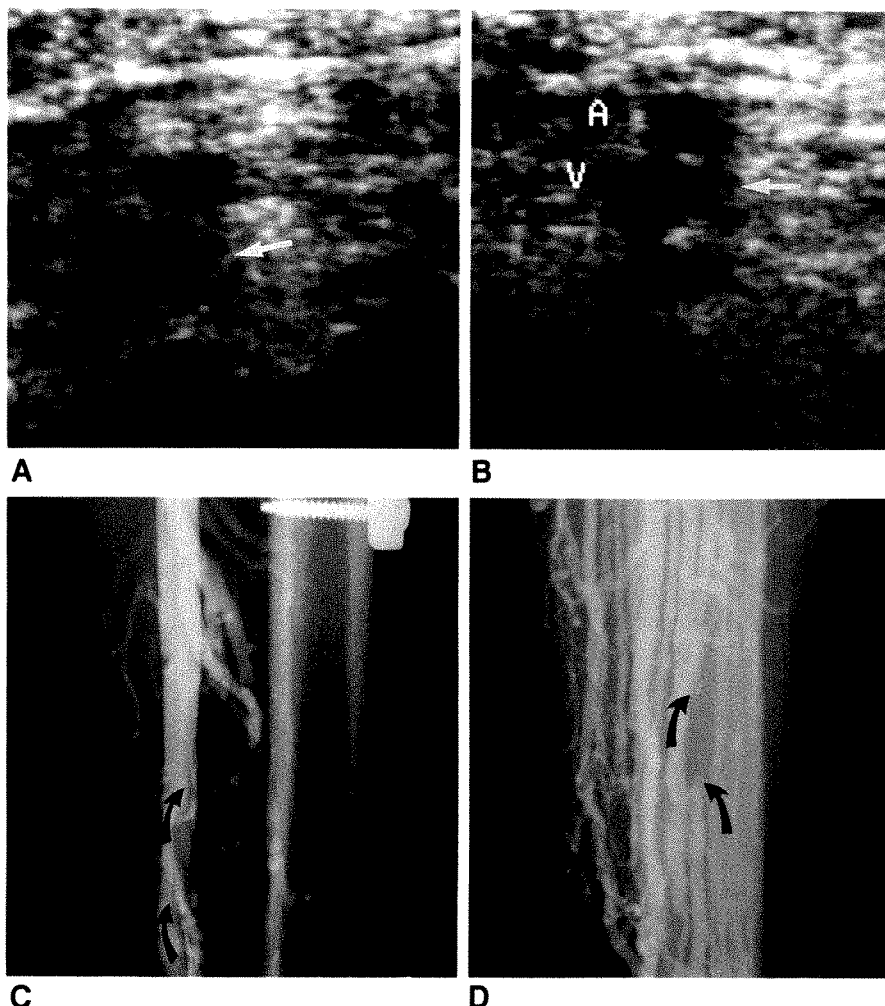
Contrast venogram obtained immediately after sonographic examination and preoperatively shows a focal nonocclusive clot (arrows) adjacent to fracture site and in agreement with abnormality seen on compression sonogram. Compression sonography clearly delineated focal noncompressibility despite adjacent soft-tissue swelling around fracture. This was evident on initial examination in four patients.
